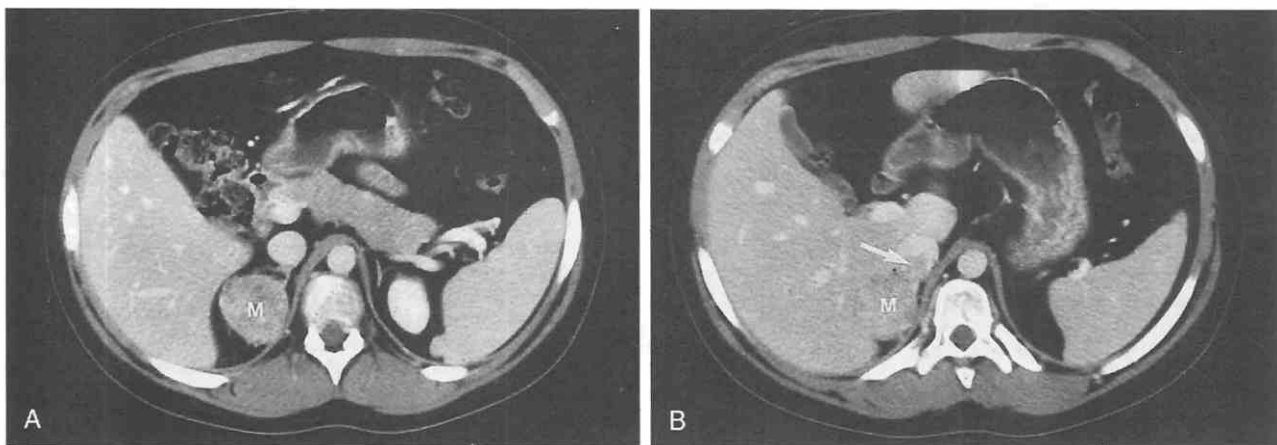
Right adrenal cortical carcinoma with intracaval extension in a 9-year-old girl with Cushing's syndrome. A, Contrast-enhanced CT axial image through the upper abdomen shows a 3-cm, solid, right adrenal mass of inhomogeneous attenuation. The mass has slightly irregular margins with thin strands extending into the pararenal fat posteriorly. The inferior vena cava enhances homogeneously at this level. B, Contrast-enhanced CT axial image through the upper abdomen. The right adrenal mass is difficult to separate from the overlying liver. Thin strands are again visible extending from the mass into the pararenal fat adjacent to the right diaphragmatic crux. In addition, there is an irregular intraluminal filling defect within the inferior vena cava, consistent with intravascular extension of the adrenal tumor.
